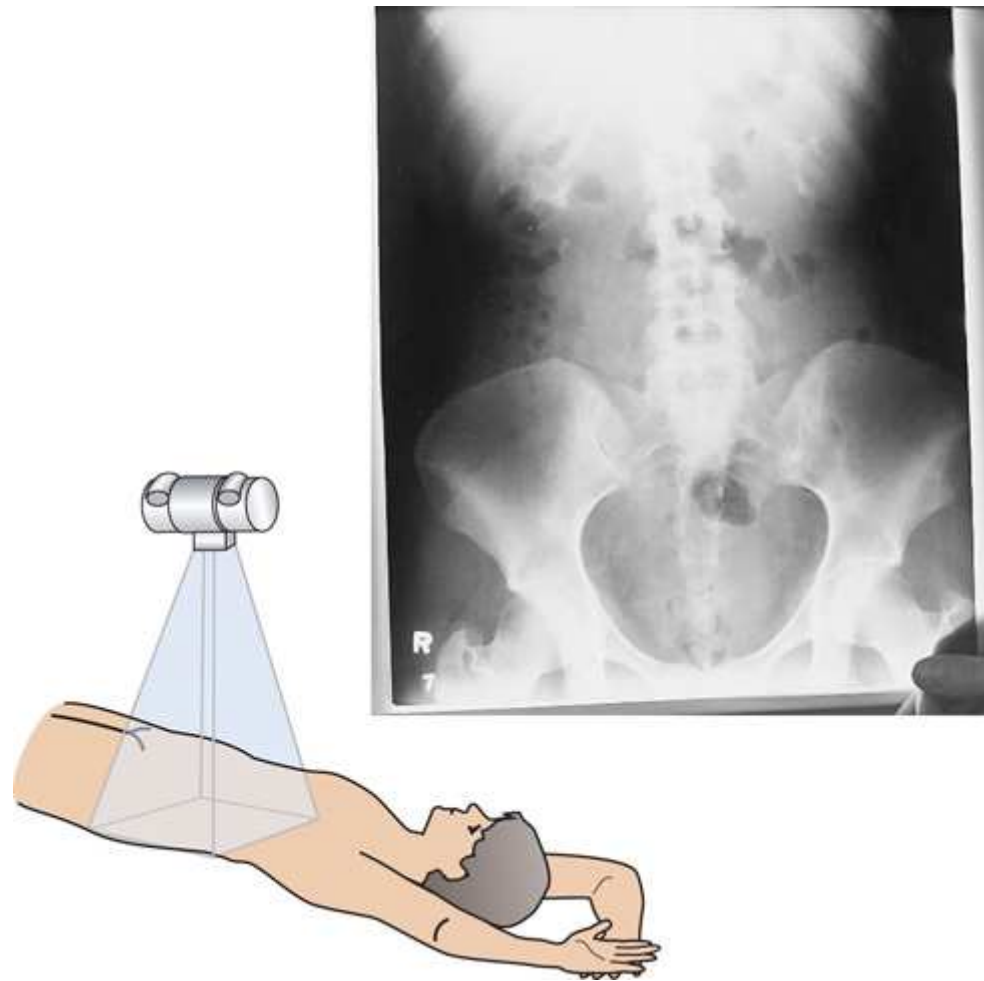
Conventional radiograph superimposes anatomy and yields one diagnostic image with fixed density and contrast.
